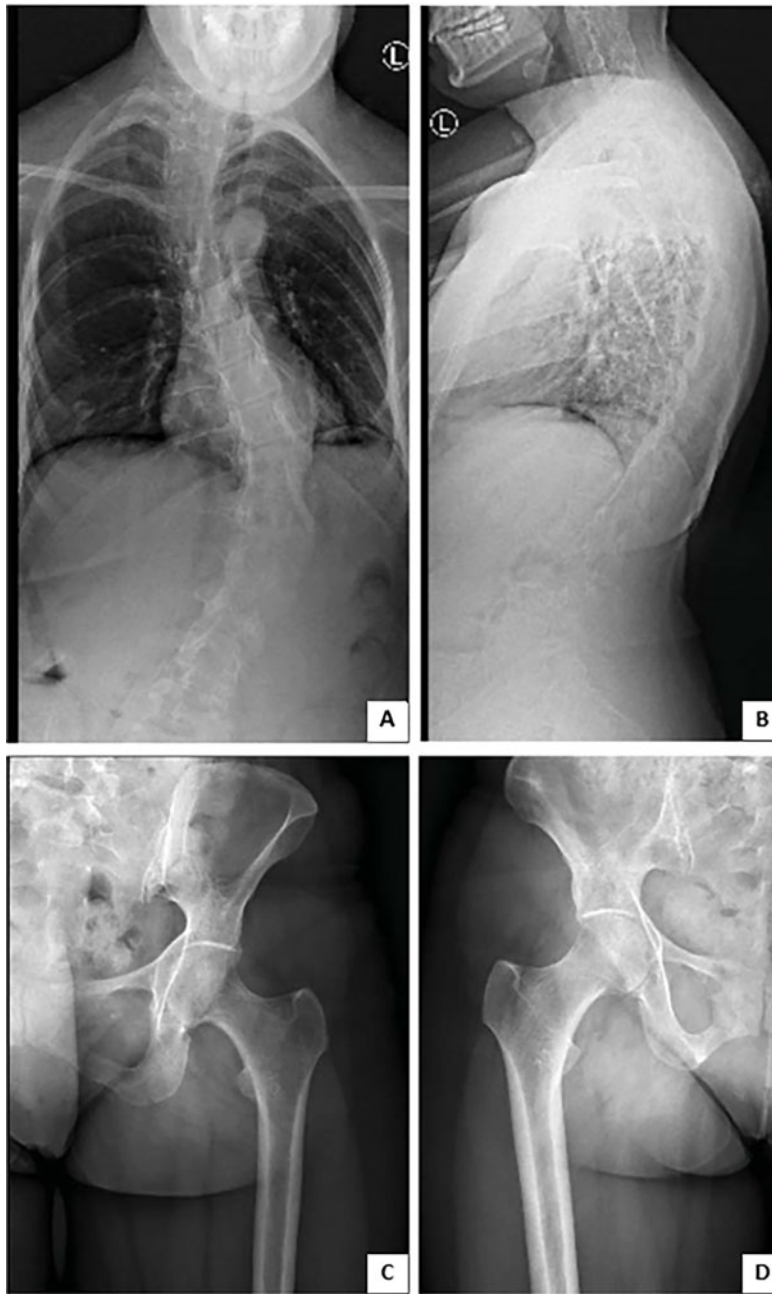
Radiographic findings. (A–B) 2020 posteroanterior and lateral x-rays, respectively, demonstrating left convex curvature of the thoracolumbar spine with Cobb angle of 53 degrees. (C–D) 2021 left hip and right hip x-rays, respectively, demonstrating sacroiliac joint and pubic symphysis degenerative changes and bilateral mild femoral head–neck junction osteophytosis without significant joint space loss. Right posterior iliac bone has deformity related to bone graft harvest for spinal fusion.
